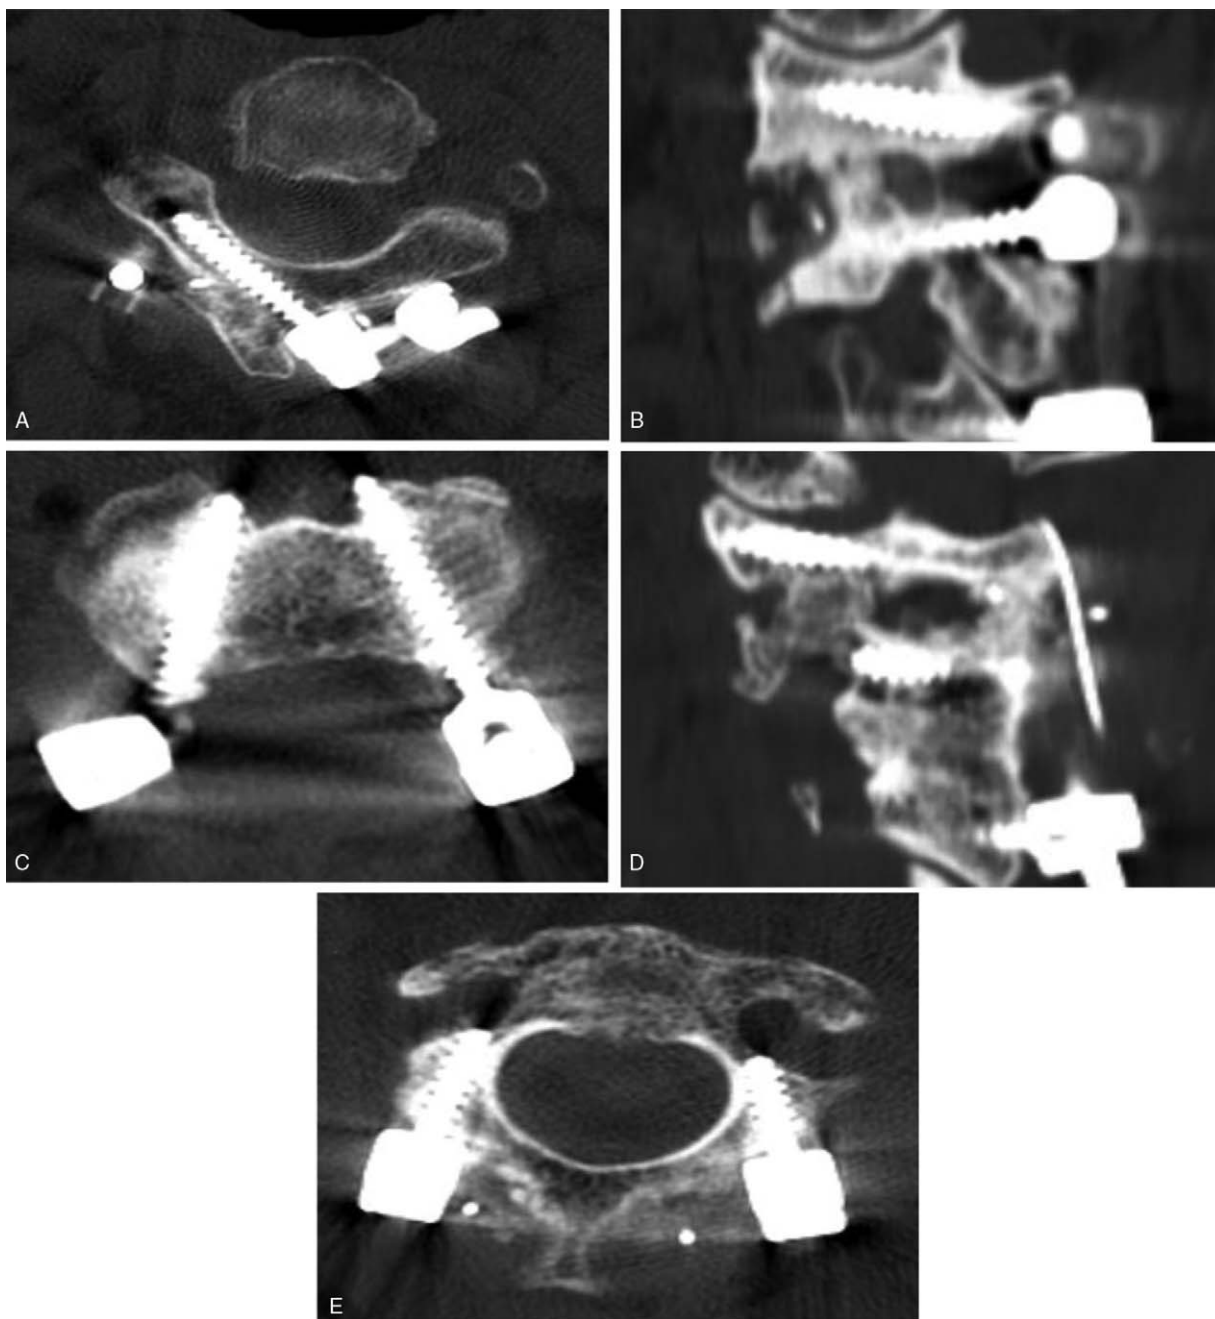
Trajectories and ideal placements of the three alternative C2 screw types on postoperative cervical CT images. (A) Translaminar screw. (B) and (C) Superior pars screw. (D) and (E) Inferior pars screw.
